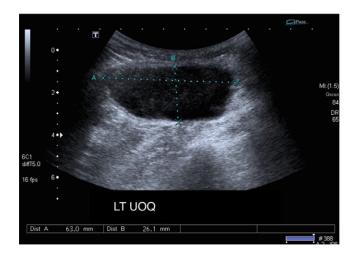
Ultrasound showing an oval-shaped seroma with thickened wall and turbid echogenicity.
